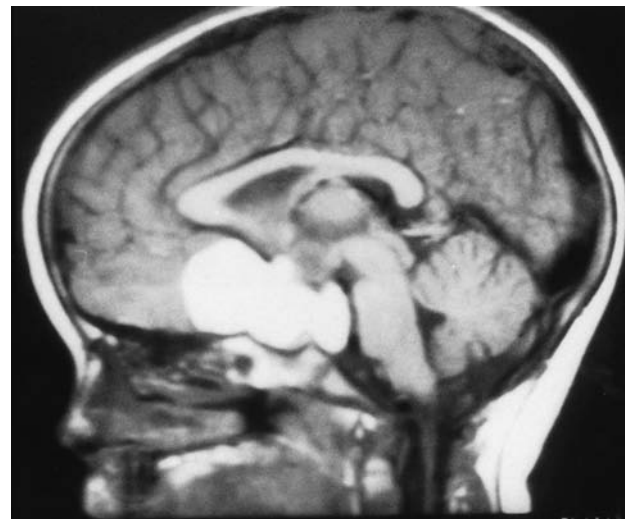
Midsagittal MRI showing a large cystic craniopharyngioma lifting the third-ventricle floor with an extension to the subfrontal region and the posterior fossa.
